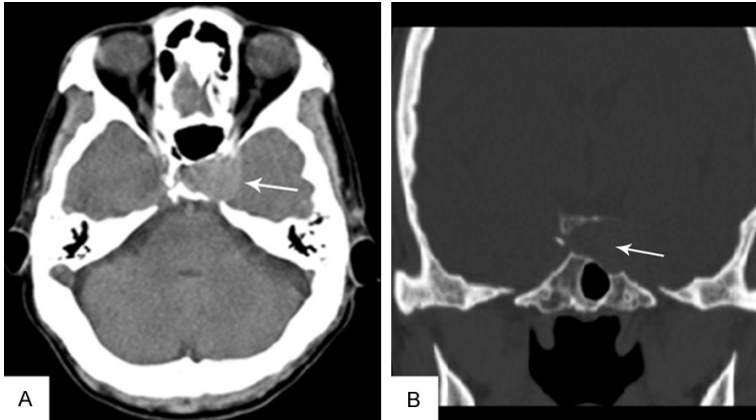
CT (A. Axial scan, soft tissue window. B. Coronal reconstruction, bone window) showed a 2.1 cm × 1.7 cm, well-defined, slightly hyperdense (mean CT attenuation value of 54 HU) mass (arrow) located in the left sellar region without calcification, hemorrhage or edema, and the local sphenoidal saddle bone was absorbed and oppressed.
